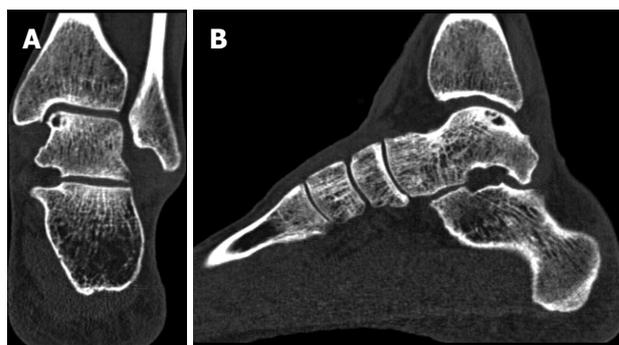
Coronal (A) and sagittal (B) computed tomography scans of a left ankle, showing an osteochondral defect of the posteromedial talar dome. Note the clear visualization of the cyst with an intact subchondral bone plate.
